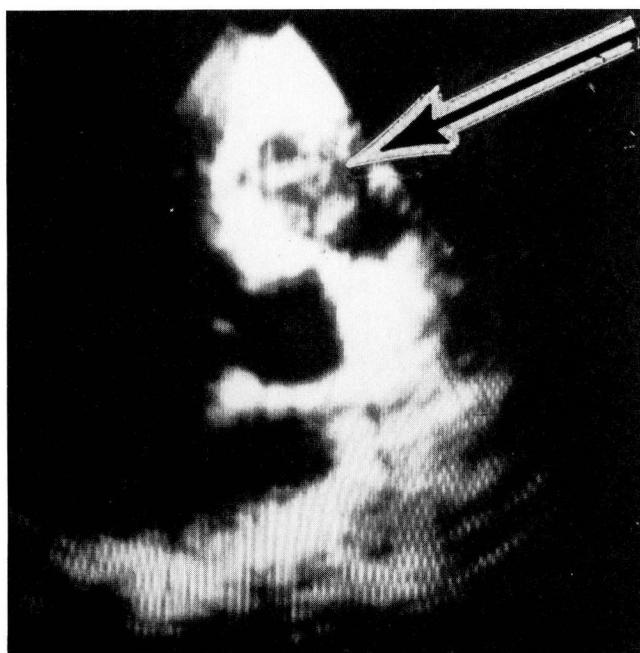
Case 1. Two-dimensional echocardiogram, apical view. The arrow points to a mass of echoes in the right ventricular apex.
